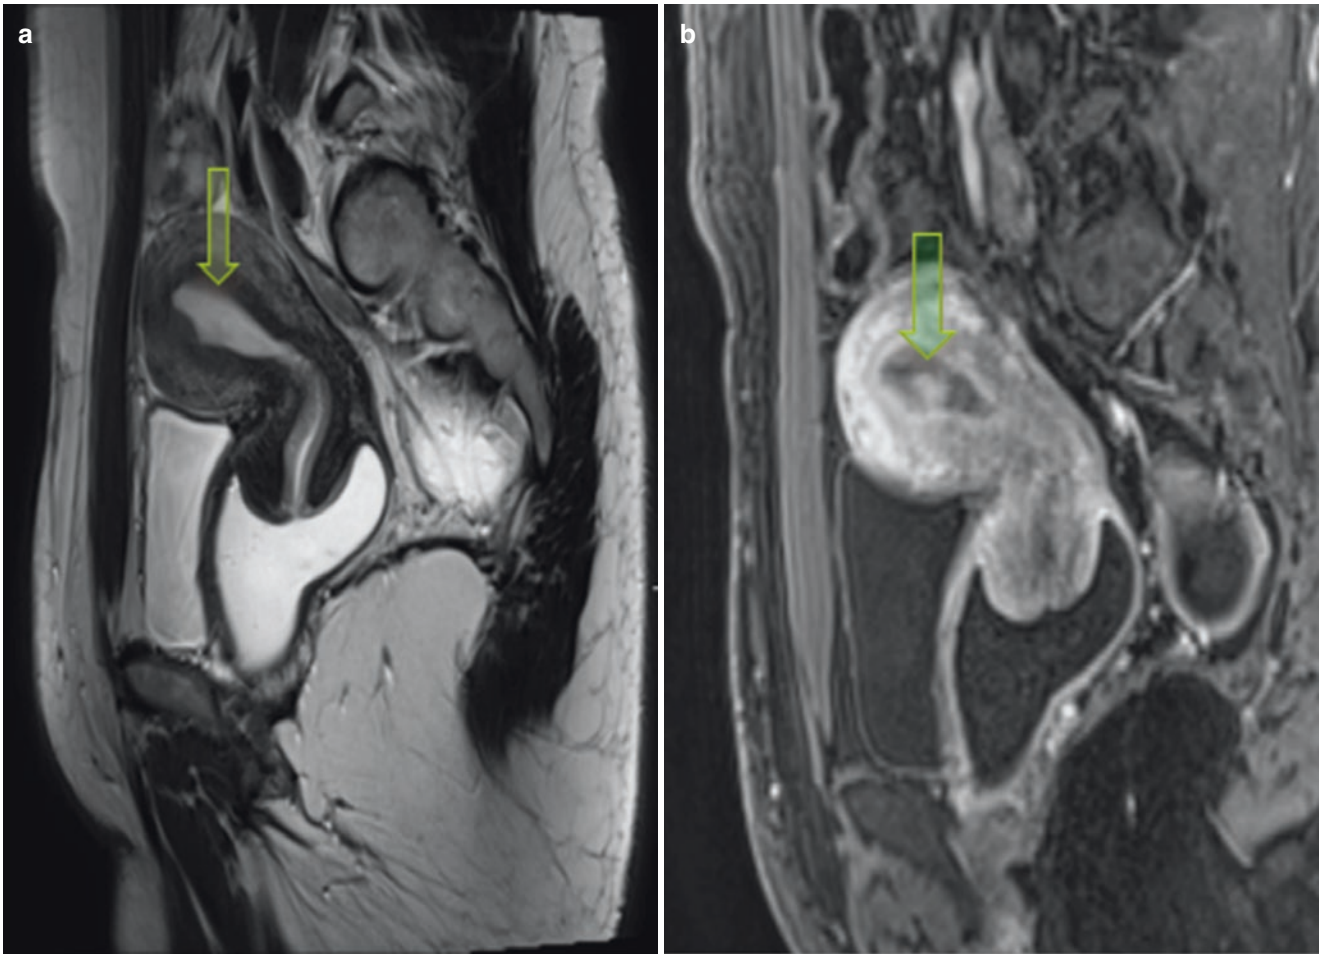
Endometrial polyp. (a) MRI of the pelvis, sagittal, T2 weighted. The polyp image is very subtle, appearing as an isointense enhancement (arrow) that may have a more heterogeneous center. (b) Same polyp, in T1-weighted image
